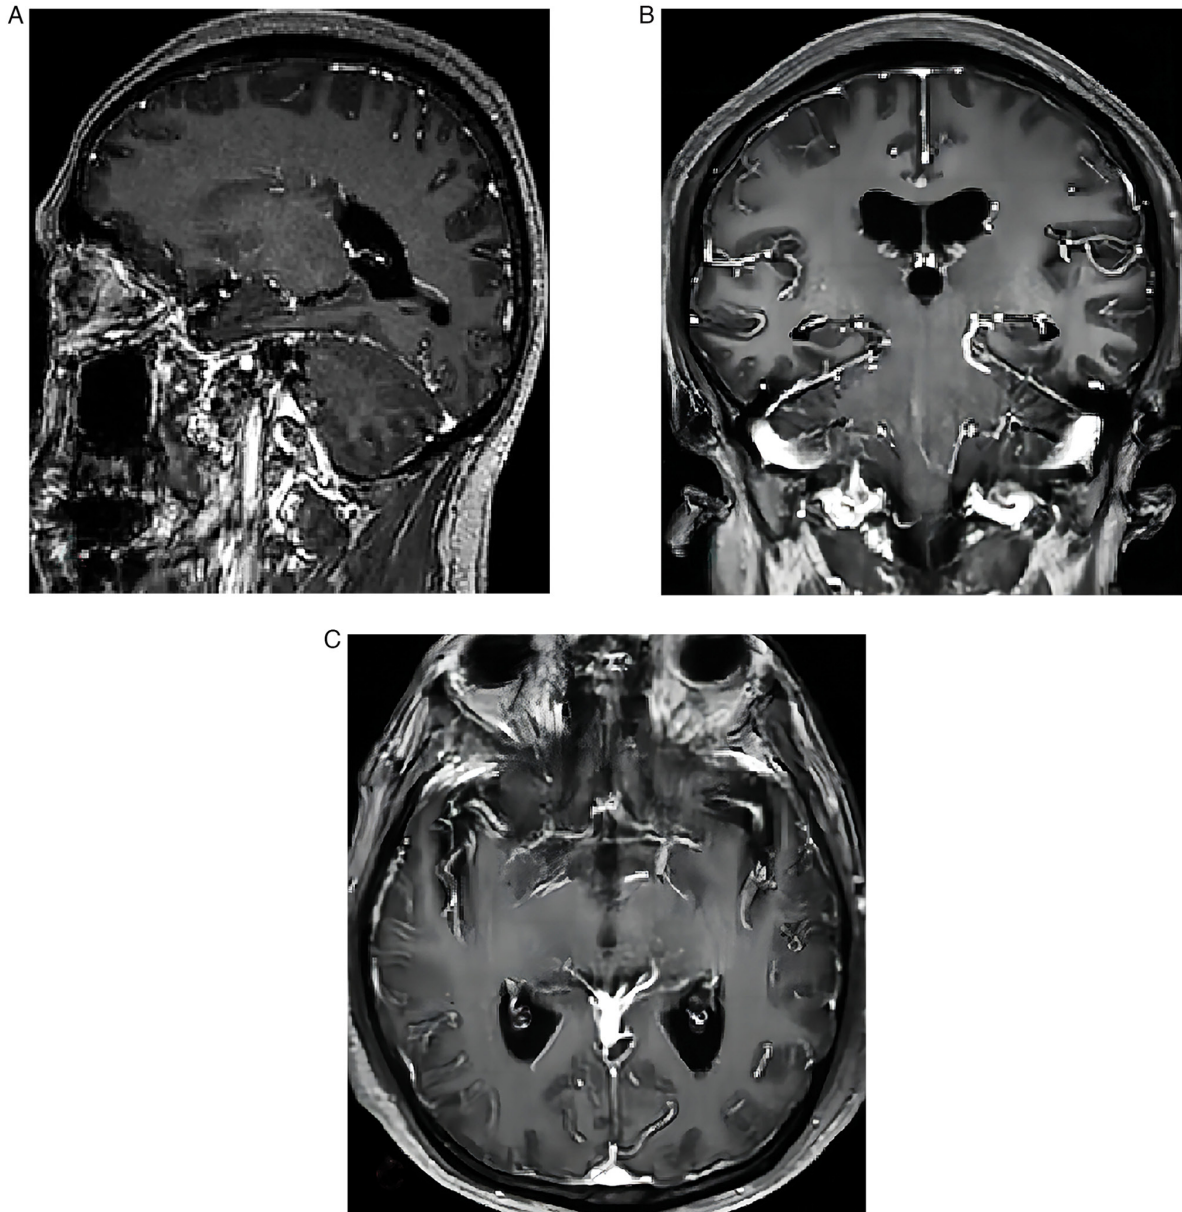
Head magnetic resonance imaging (A) plain scan and enhanced (B) coronal and (C) axial scan at admission showing cerebrovascular white matter hyperintensity, Fazekas grade 1.
